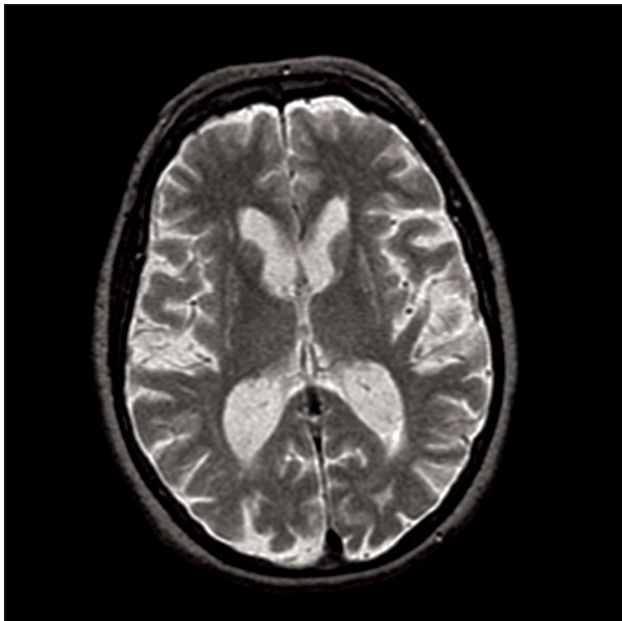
CT scan showing subcortical and cortical atrophy, basal cisterns and chamber system uniformly more voluminous, cortical sulcus slightly emphasized
